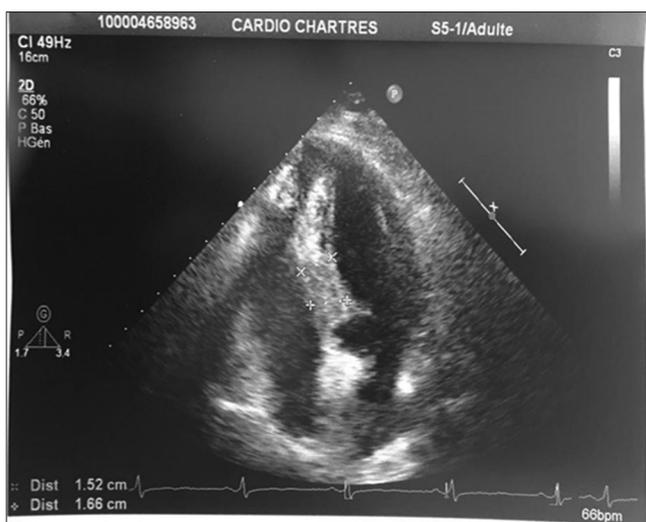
Transthoracic echocardiography showing apical and septal hypertrophy
